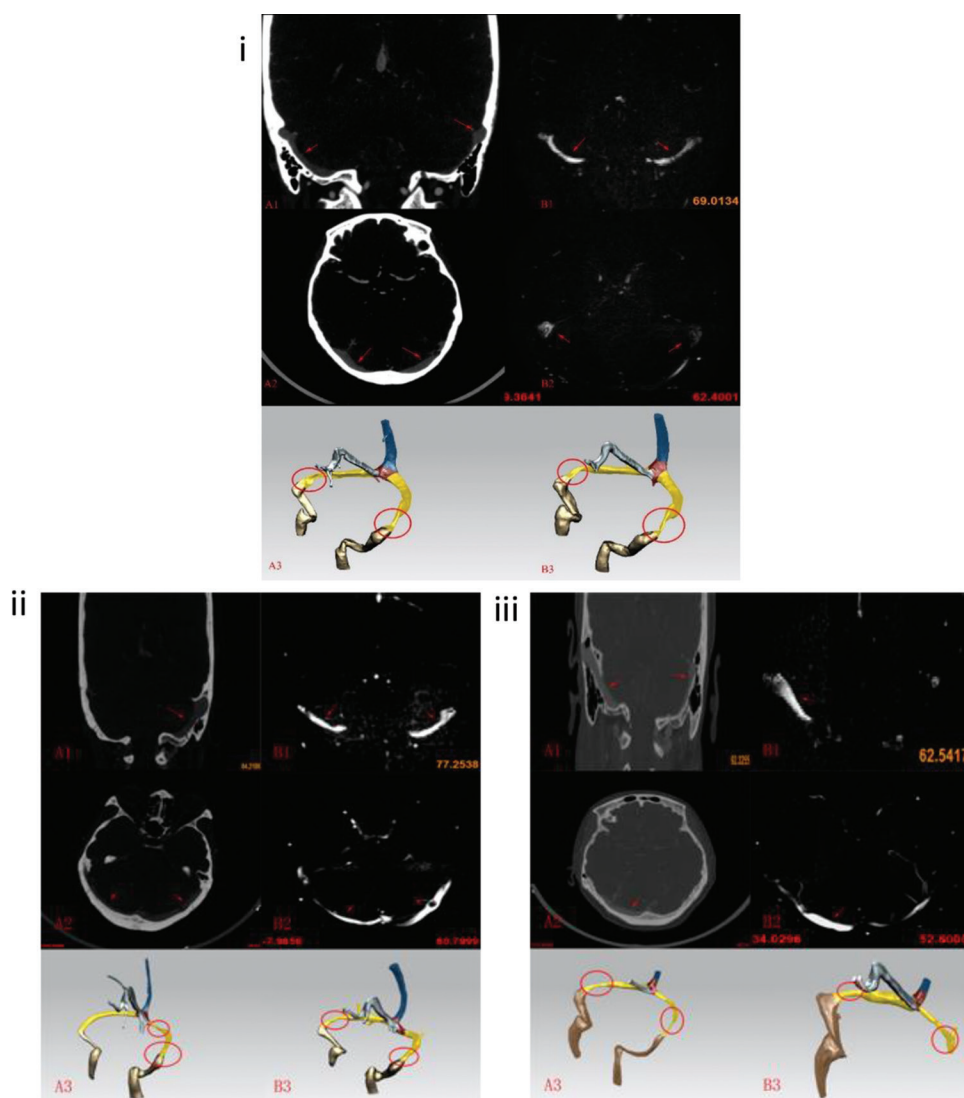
Comparison models of computed tomography venography (CTV) (images labeled by A) and magnetic resonance imaging (images labeled by B). A1 and B1 are coronal planes with transverse sinuses (indicated by red arrows); A2 and B2 are axial planes with transverse sinuses (indicated by red arrows); A3 and B3 are geometries reconstructed based on CTV and MRI images, respectively. Segments are highlighted in colors as follows: the superior sagittal sinus (blue), the left and right transverse sinuses (yellow), the left and right sigmoid sinuses (gold), the inferior sinus (silver), and the confluence of the segments (brown). Stenosis is highlighted with red circles. Panels i, ii, and iii represent Cases 3, 2, and 19, respectively.
